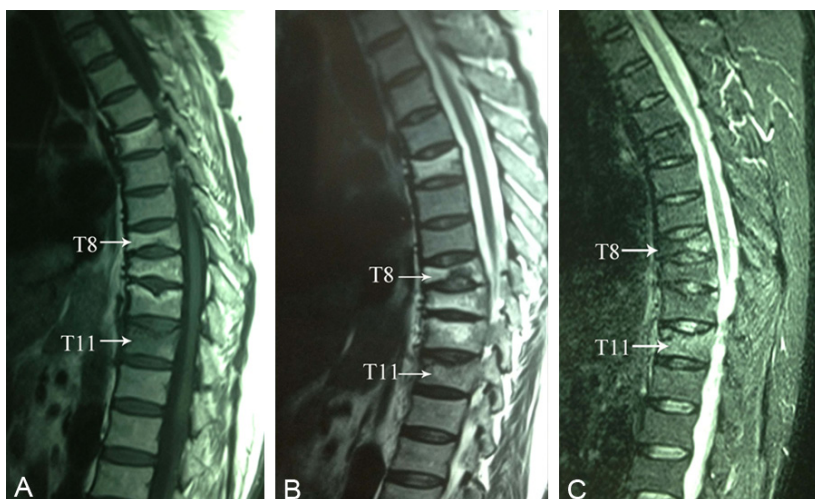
MRI scans on May 27, 2011. MRI scans of posterior part of thoracic 8 showed hypointense on T1WI, hyperintense on T2WI and STIR sequences. And MRI scans of thoracic 11 showed hypointense on T1WI, hyperintense on T2WI and STIR sequences. The obvious edema signal is considered as evidence of fresh fracture in painful responsible vertebrae of T8 and T11.
